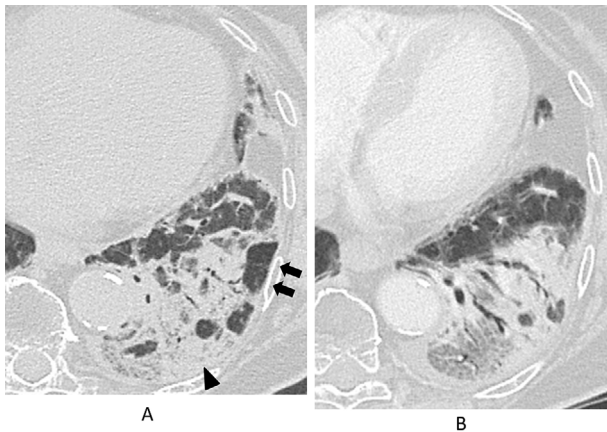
Follow-up CT findings in Case 2. (A) Air-space consolidation with traction bronchiectasis (arrowhead) was observed in Case 2 at the first visit. In the subpleural region, polygonal increased attenuation was also revealed (arrows). (B) Consolidation, which had been observed on admission, deteriorated with a remarkable loss of lung volume two days after admission.
